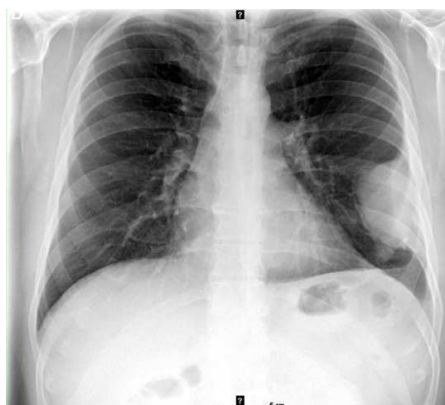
A 42-year-old man with increasing pain in the left hemithorax. X-ray showing a solid lesion in the left hemithorax of pleural origin, with ipsilateral atelectasis and pleural effusion.
